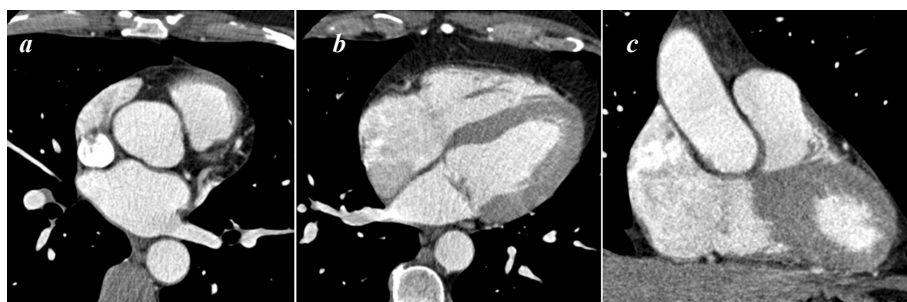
Cardiac CT, pre-bolus contrast enhancement, arterial phase (a, b - axial reconstruction, c - coronal reconstruction). Increased extent of contrasting and homogeneity of the right cardiac chambers. Sufficient and homogeneous CA filling is maintained in the left cardiac chambers.
